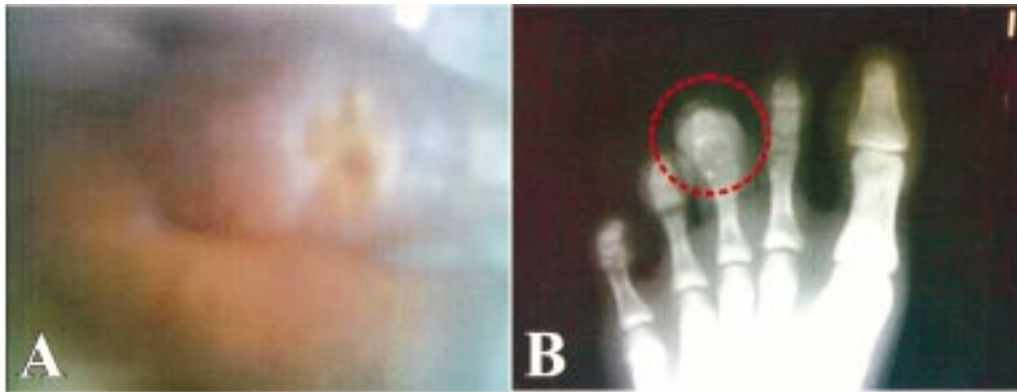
Prior to institution of anti-tubercular treatment. A. External appearance of the dorsal aspect of the third toe of the left foot showing discharging sinus at initial presentation. B. X-ray AP view of the left foot (showing lytic lesion of the 3rd digit).
